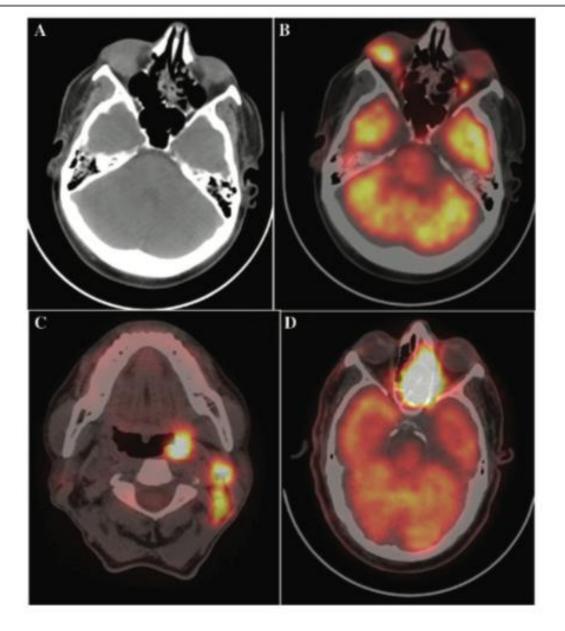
(A) CT of a 46-year-old man showing a homogeneous soft tissue lesion in the right orbit. (B) Intense FDG uptake is seen in the orbital lesion, which was proven to be diffuse large B cell lymphoma. (C) Tonsillar lymphoma in a 53-year-old man of T cell subtype. (D) Lymphoma of T cell subtype involving the ethmoid sinus on the left side in a 62-year-old male patient. All these lesions were found on PET/CT scans that were referred for staging purposes.
